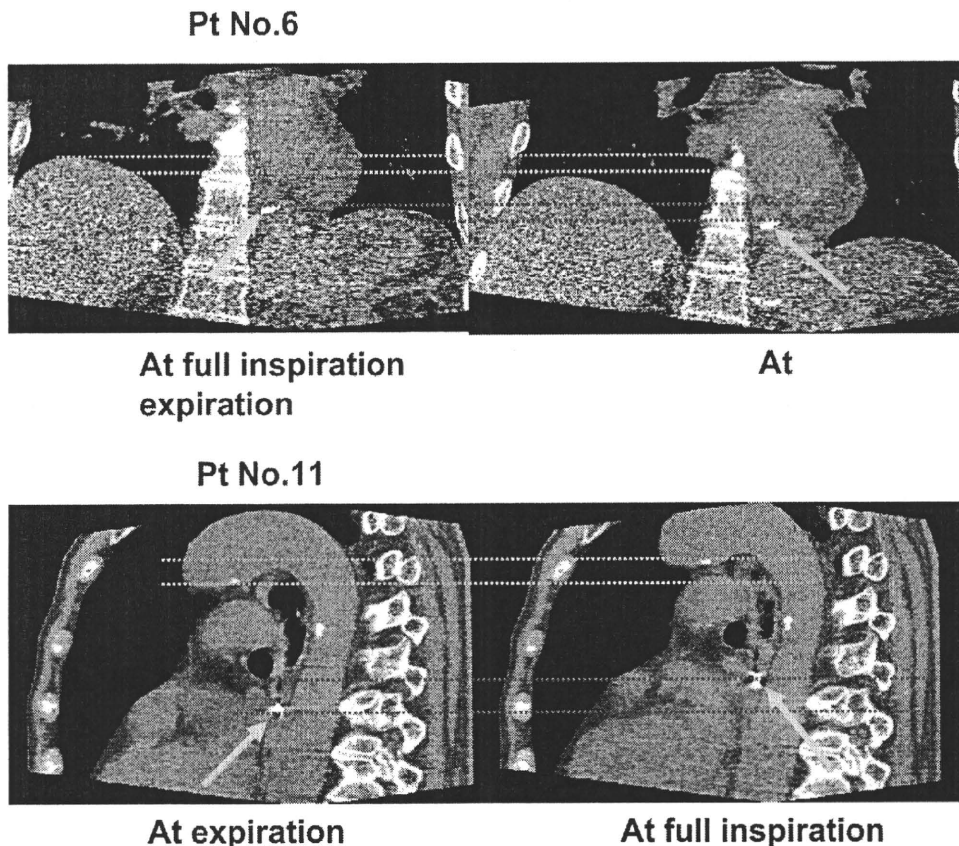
Four-dimensional CT images of end-expiration and end-inspiration taken during normal breathing. (A) Coronal of Patient 6. (B) Sagittal of Patient 11.
